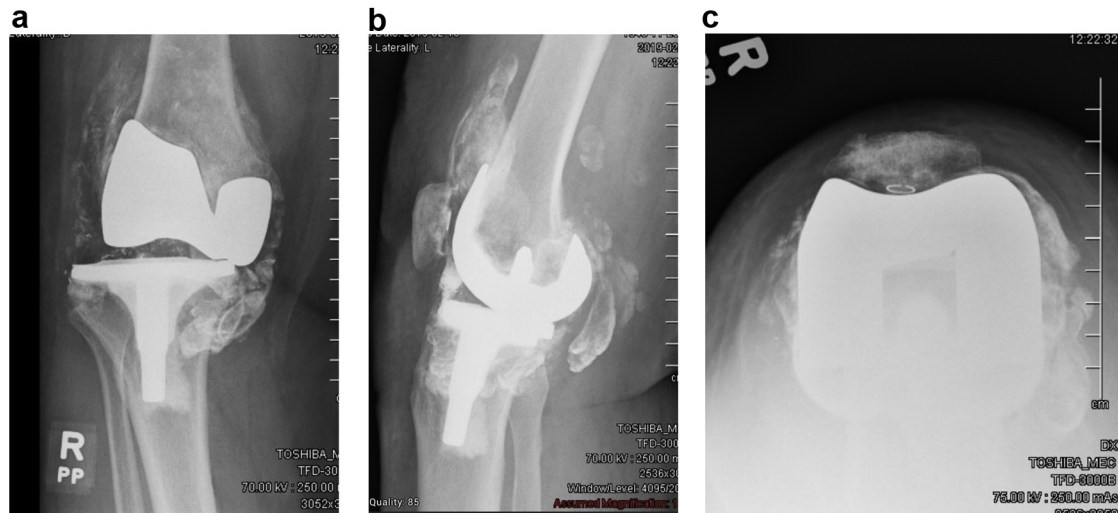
Anteroposterior (a), lateral (b), and sunrise (c) radiographs of a failed oxidized zirconium TKA with resultant Oxinium “arthrogram.”
